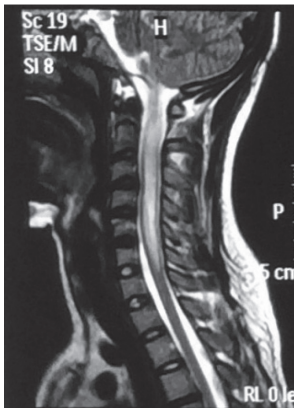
MRI spinal cord shows T2 hyperintensities starting in the medulla and extending to cervical cord C6-C7 level.
